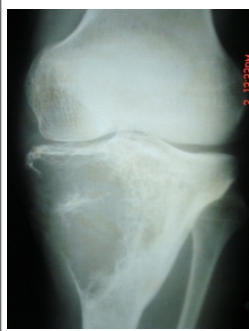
Pre-op radiograph AP view.
